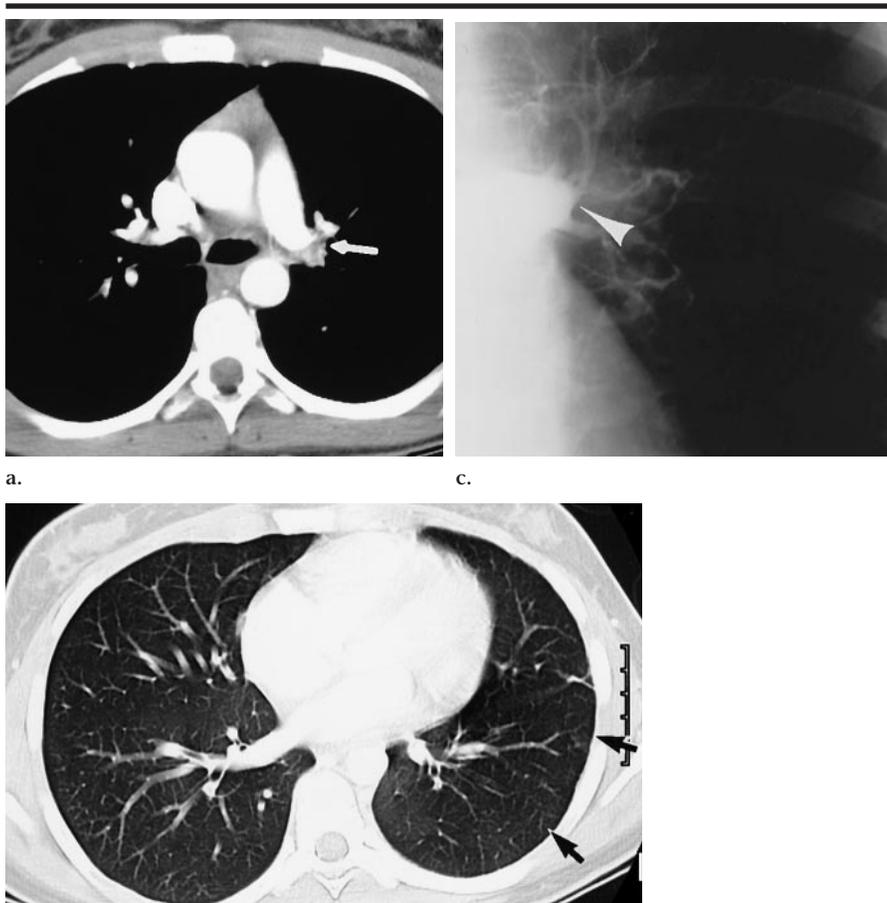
CTE in an 18-year-old woman. (a) Transverse CT angiogram shows abrupt occlusion of the left pulmonary artery (arrow). No flow was identified on images obtained at lower levels. (b) Transverse CT angiogram obtained with lung windows demonstrates decreased perfusion to the left lung (arrows), with decreased size of segmental vessels. (c) Anteroposterior conventional angiogram shows abrupt tapering of left pulmonary artery (arrowhead).
